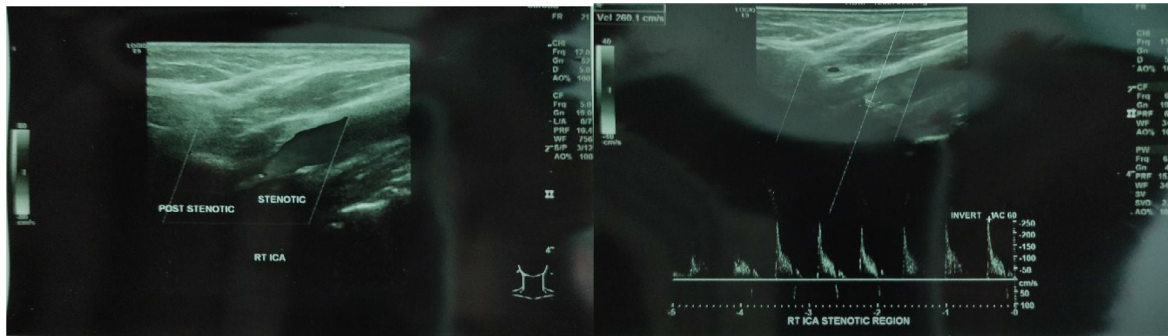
Right carotid Doppler showed right ICA stenosis.
